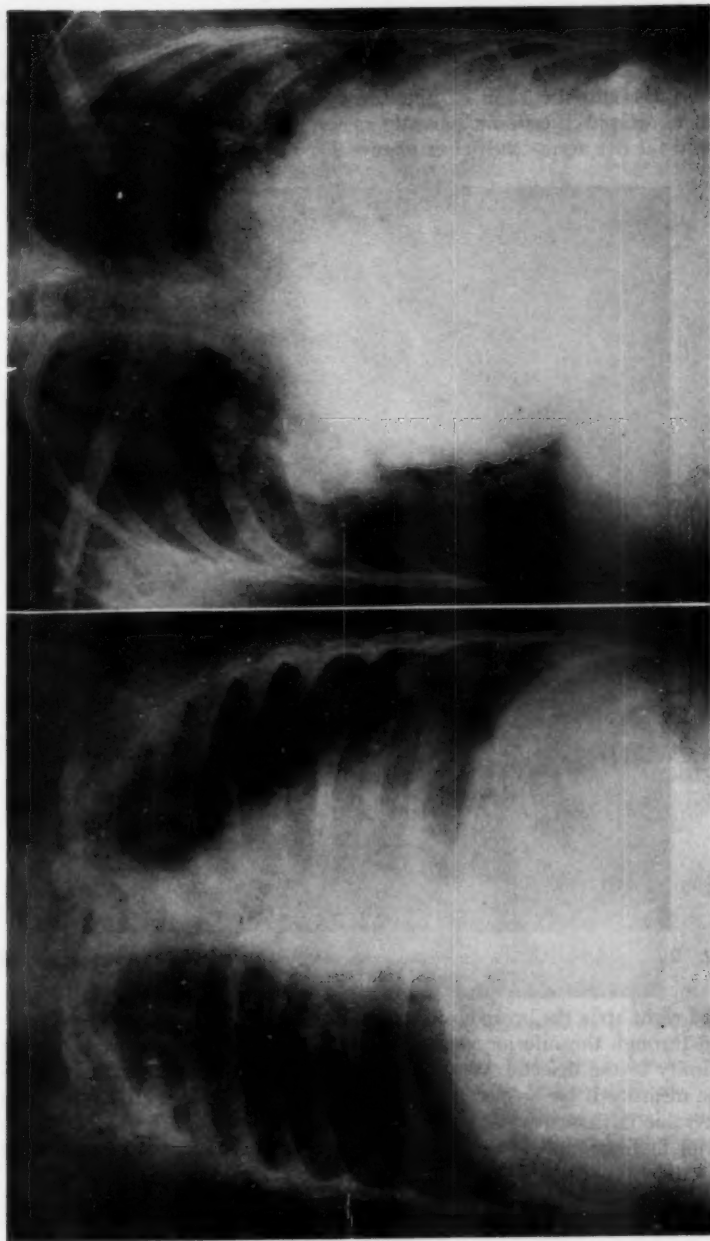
(left) A-P x-ray of child, age 2 years, with interatrial septal defect, uncomplicated. (right) A-P x-ray of adult with uncomplicated atrial septal defect.
